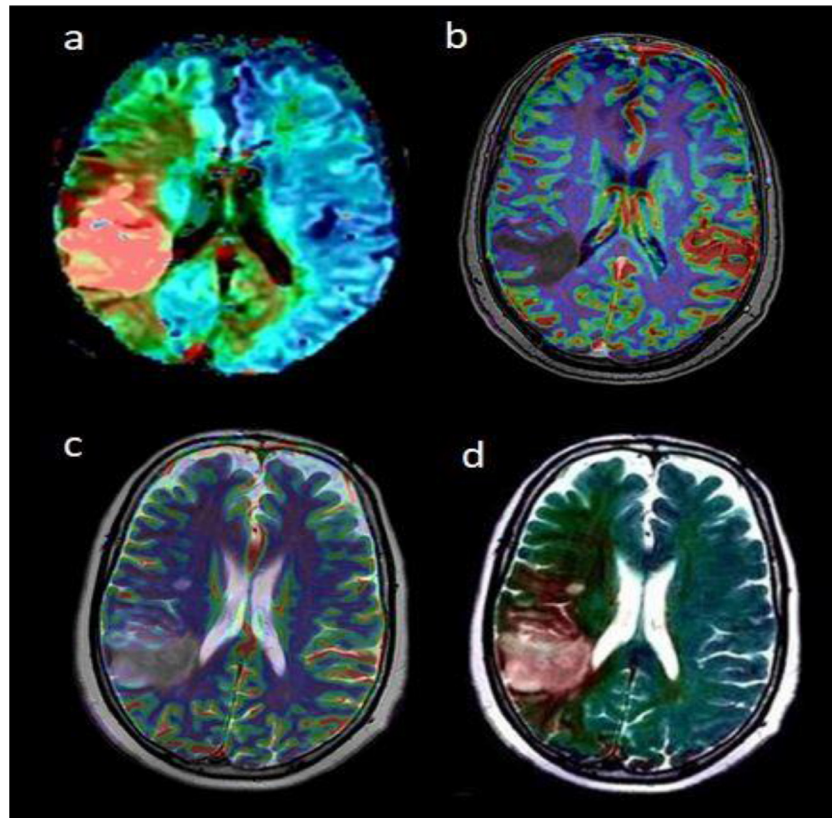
Advanced secondary maps. (a) TTP/DWI mismatch, (b) CBF/T1 mismatch, (c) rCBV/T2, (d) MTT/T2.
